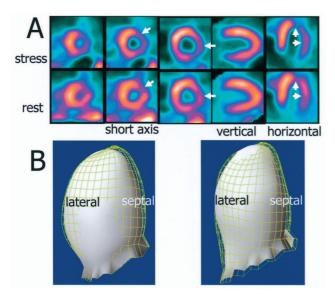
(A) Single-photon emission computed tomographic images showing non-reversible perfusion defect in the anterolateral segments (*arrows*), (B) Quantitative gated SPECT showing akinesis in the lateral segments after stress (*left*) and at rest (*right*).
